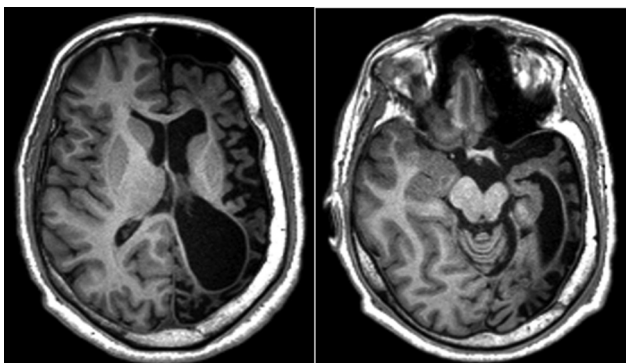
MRI brain T1 axial section shows significant left hemispheric atrophy along with ex vacuo dilatation of ventricles and atrophy of crus cerebri. The basal ganglia and thalamus are relatively spared. Thickened calvarium on the left side and hyperpneumatization of frontal sinuses is also noted.
